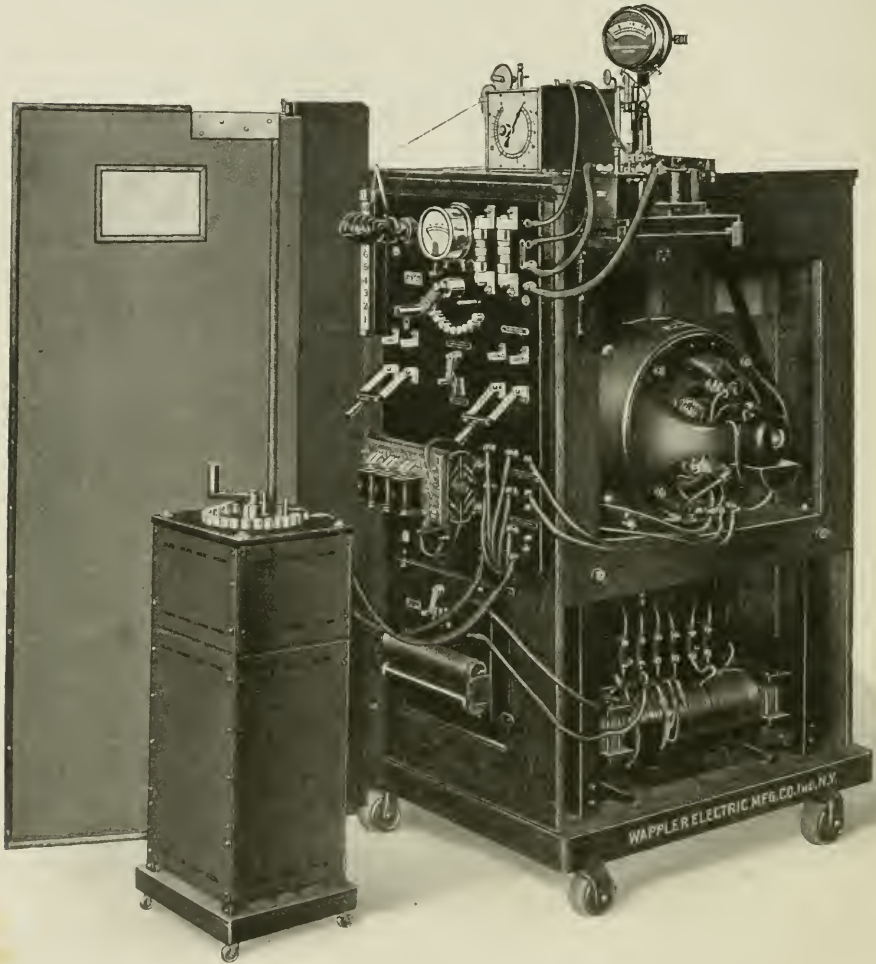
Direct current interrupterless transformer, showing rear of machine and switchboard with large capacity rheostat, serial timer with mercury dip, X-ray meter and lead-lined protection screen attached.
